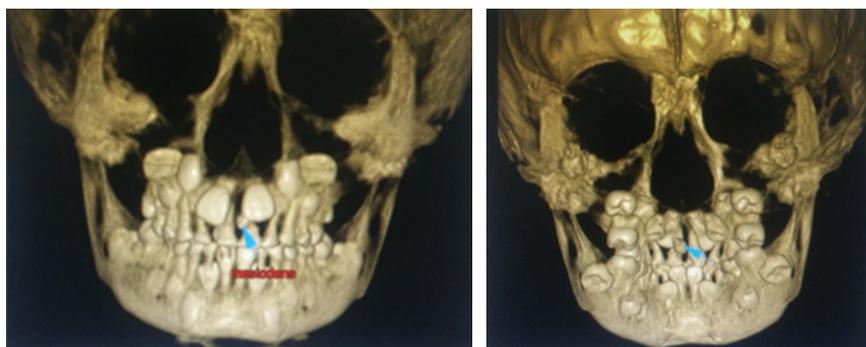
A single mesiodens present between the upper central incisors seen in 3D view of CBCT (a) AP view (b) PA view.
